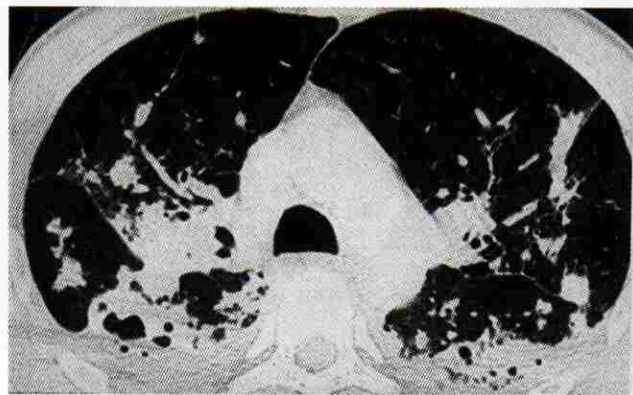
High-resolution computed tomogram of patient with postprimary tuberculosis. Note multiple regions of cavitation with consolidation in the posterior aspects of the superior segments of both lower lobes.
